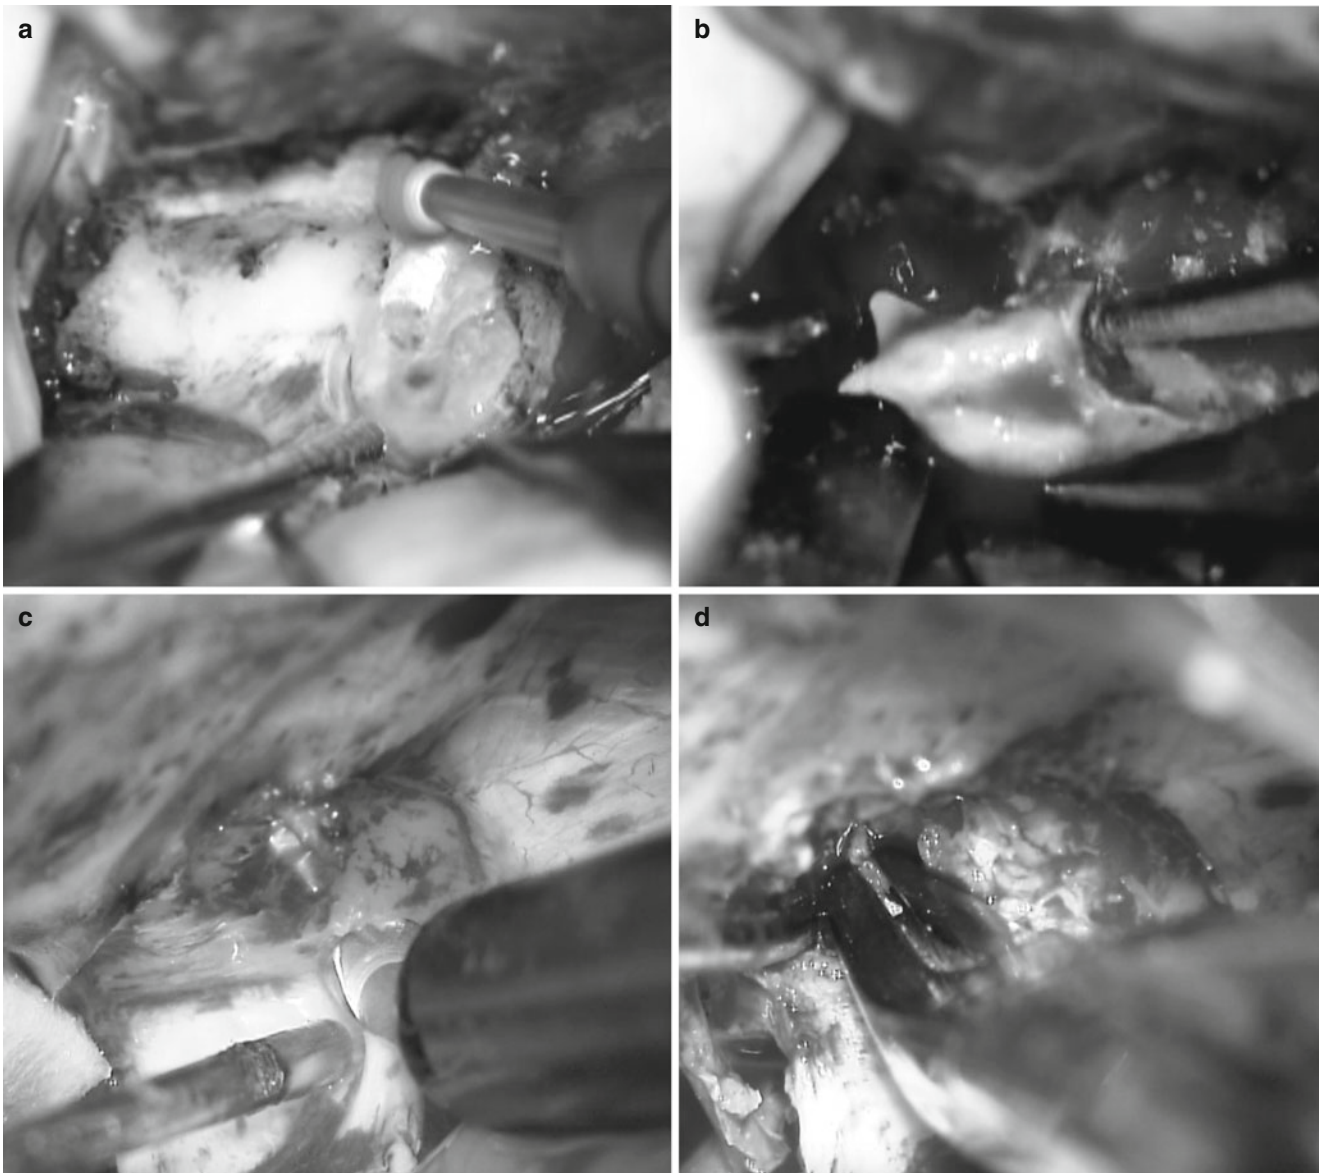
In the early stage of our series, en bloc anterior clinoidectomy was performed with high-speed drills (a, b). Anterior clinoidectomy has been converted to a piecemeal method using an ultrasonic bone curette (c) and microrongeur (d)
